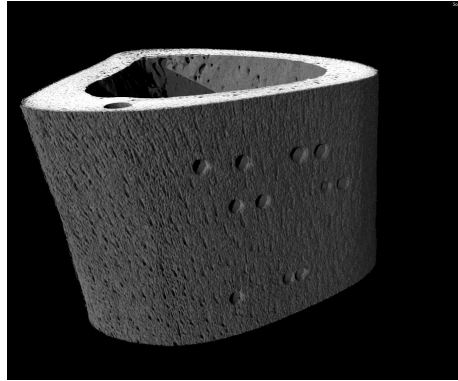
Reconstructed ablated bone after computed tomography (CT). The holes shown in the image correspond to the ablated areas.
